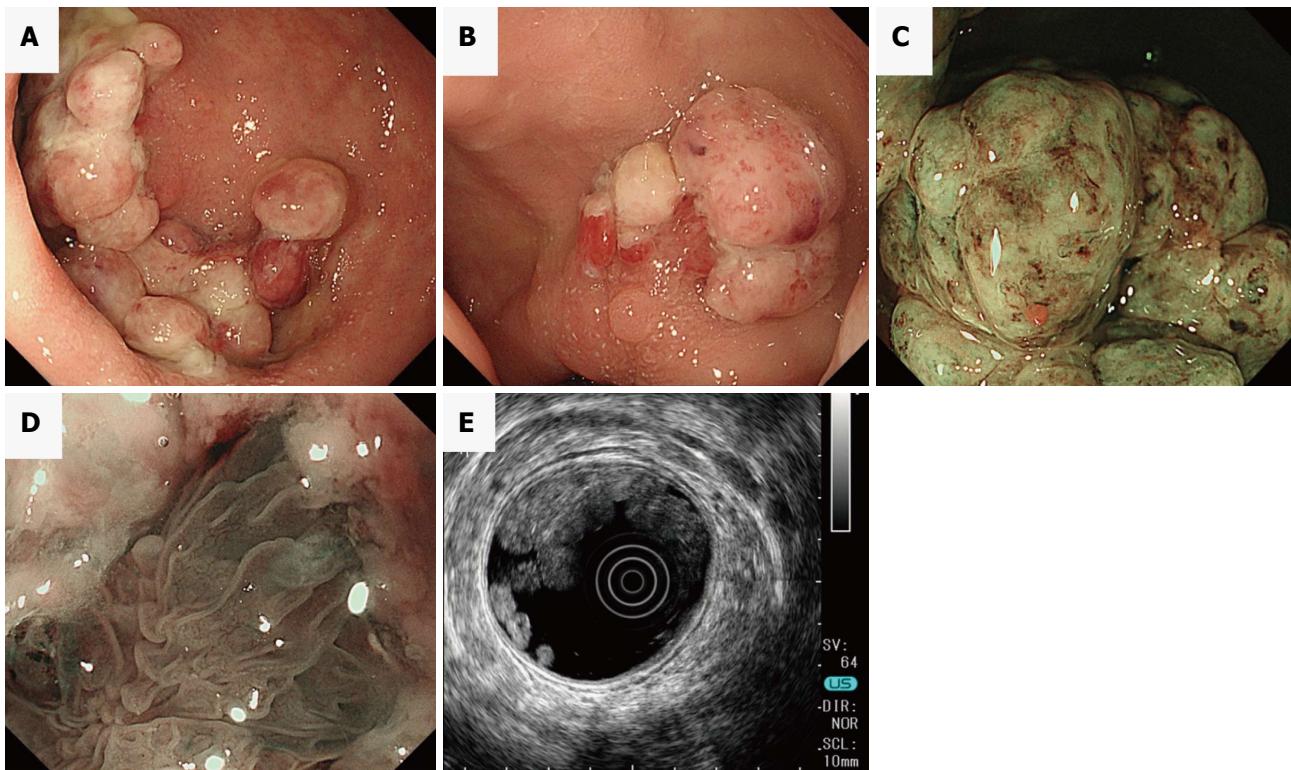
Endoscopic findings of multiple inflammatory polyps. A and B: Caps of fibrinopurulent exudate from the sigmoid colon to the rectum interspersed with normal colonic mucosa; C and D: Magnifying endoscopy shows an area in the cap of amorphous fibrinopurulent exudate and tortuous and long branching crypts under the cap; E: Endoscopic ultrasonography showed significant thickening of the colonic mucosa layers.
